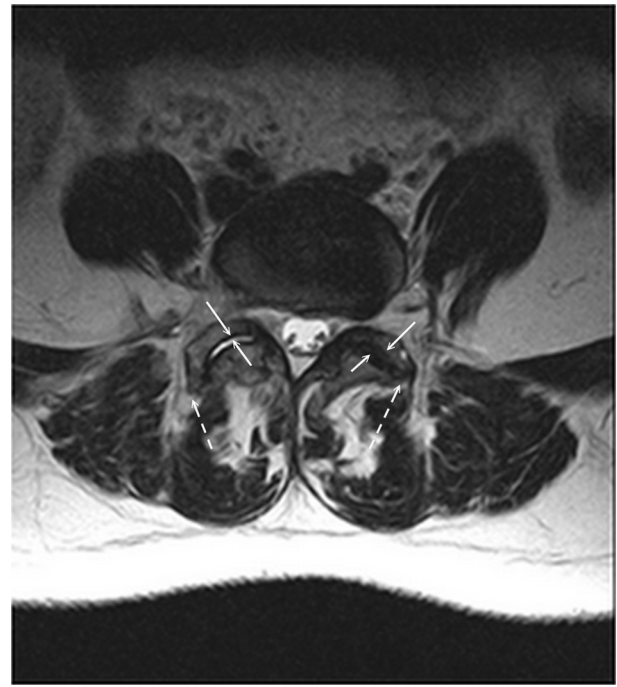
Facet-joint degeneration was graded using axial T2-weighted magnetic resonance images based on Grogan's classification, including grades of cartilage, subchondral sclerosis, and osteophytes. The three grades of Grogan's classification were summed up into a facet degeneration index (FDI). In this image, cartilage degenerations were Grade 2 for the right side and Grade 3 for the left side (short arrows), subchondral scleroses were Grade 2 for the right side and Grade 3 for the left side (long arrows), and osteophytes were Grade 3 for the right side and Grade 3 for the left side (broken arrows). The FDI was 7 for the right facet joint and 9 for the left; thus, the higher FDI value of 9 was recorded for analysis of the facet-joint degeneration of L₄₋₅. FDI, facet degeneration index.
